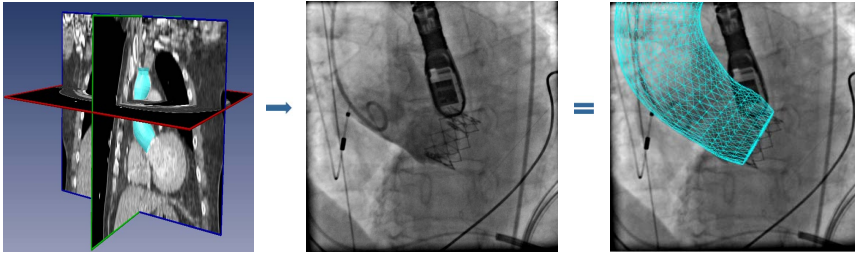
Direct 3D to 2D fusion of the aortic root model to provide visual guidance for transcatheter aortic valve implantation. Left: Pre-operative 3D CT with the automatically segmented aortic root mesh. Middle: A 2D fluoroscopic image with contrast injection inside the aortic root. Right: Model fusion result. Direct 3D to 2D fusion is difficult and manual interaction may be required.
